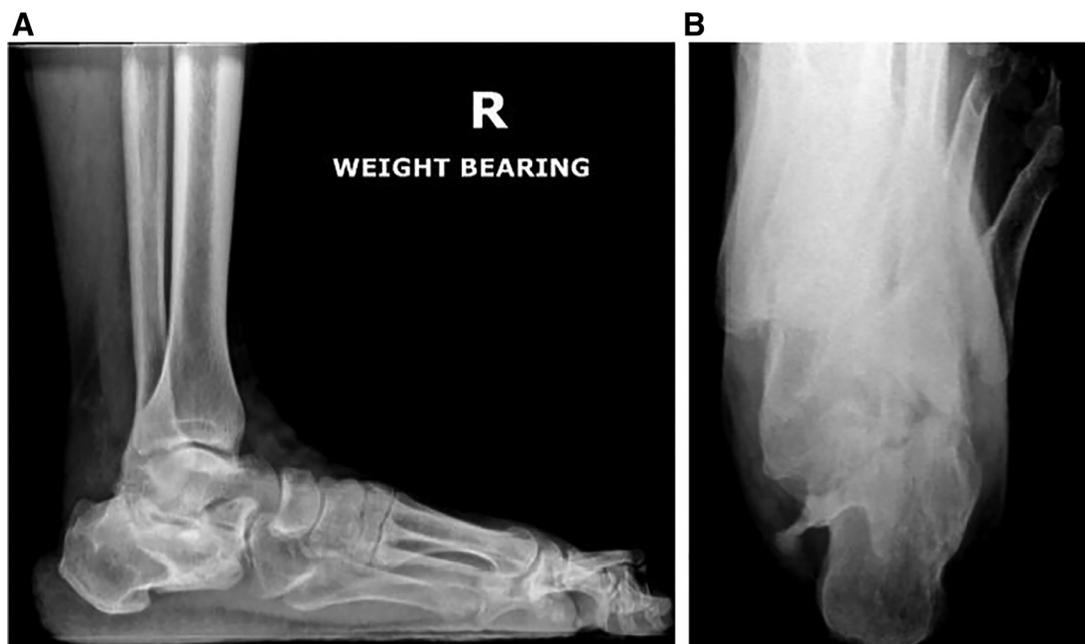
Preoperative lateral ankle (A) and axial (B) radiographs.
